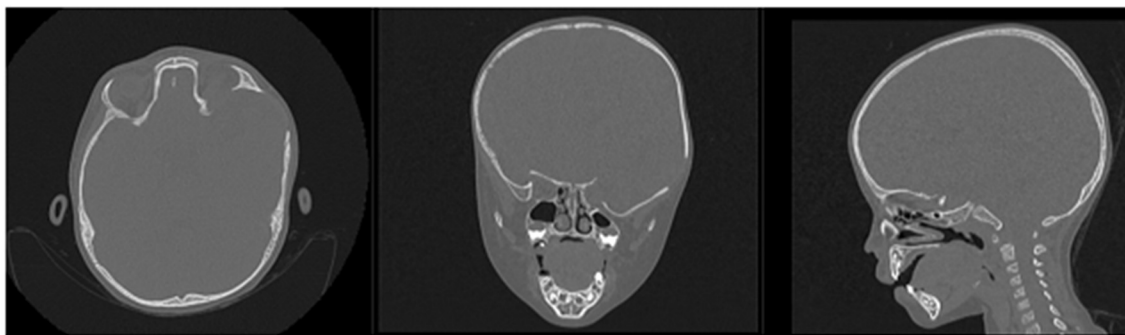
Computed Tomography (CAT). Left temporoparietal cranial defect, solution of continuity in the roof of the orbit and temporoparietal region.
